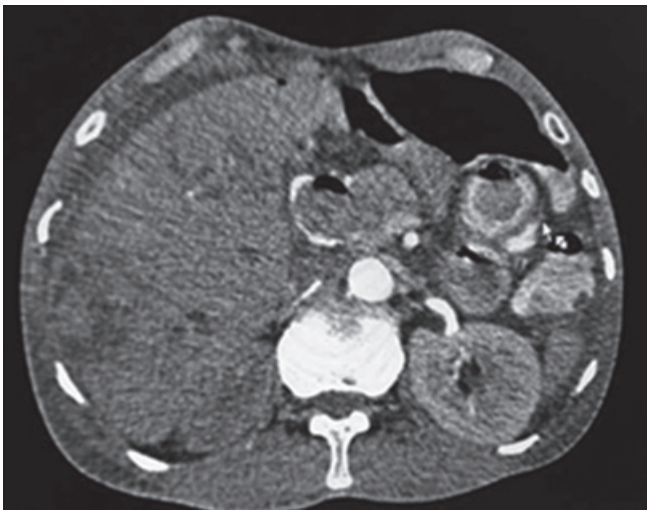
Axial CT revealing dilated CBD filled with blood clots with active contrast extravasation. Air is also noted within CBD (post ERCP pnbilia)
